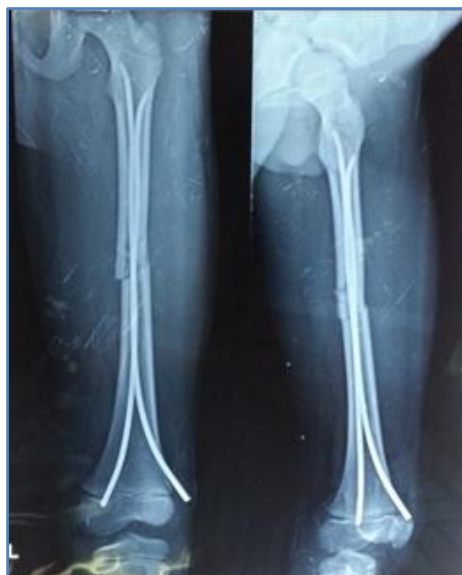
X-ray images of fracture shaft femur of 9 year old boy: immediate post op
